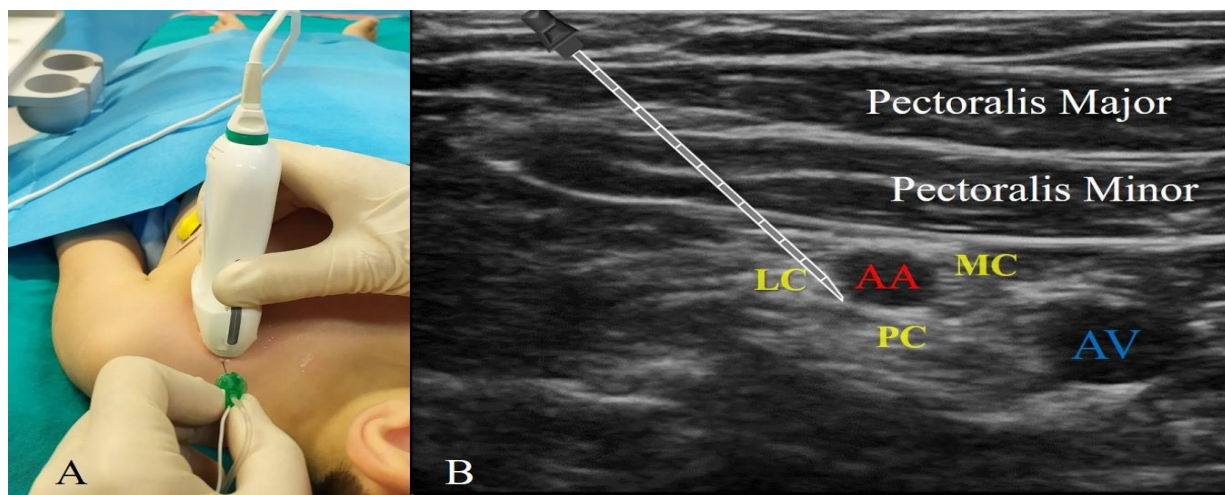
A) Patient and ultrasound probe orientation for infraclavicular block. B) Sonographic image of pediatric infraclavicular block, LC: Lateral cord, PC: Posterior cord, MC: Medial Cord, AA: Axillary Artery, AV: Axillary vein.
